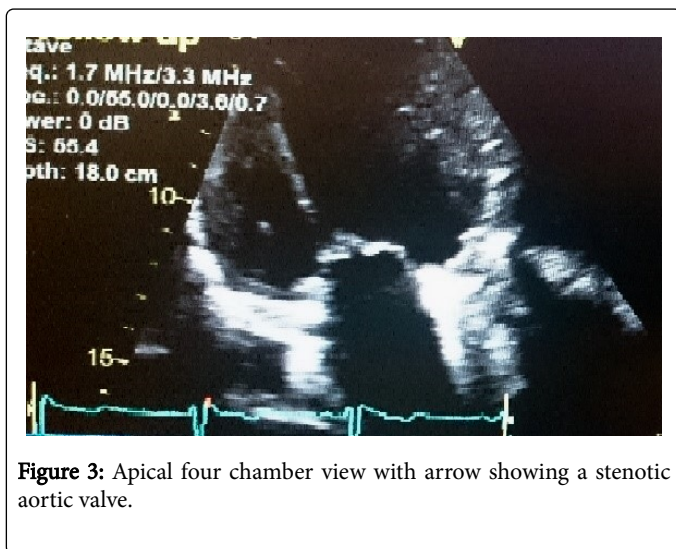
Apical four chamber view with arrow showing a stenotic aortic valve.
